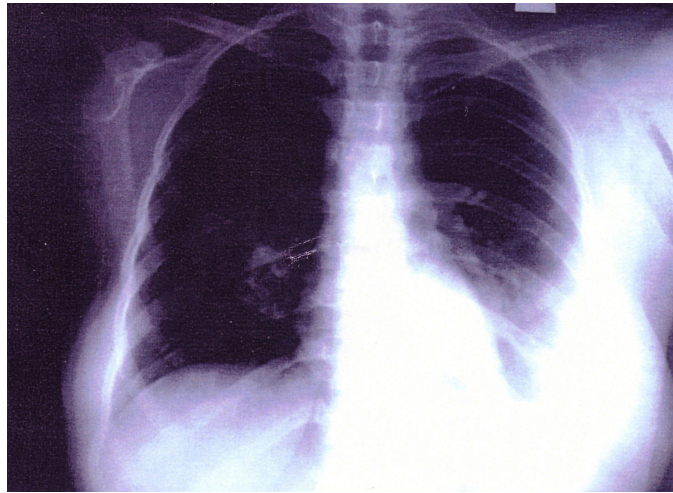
Chest X-Ray of the right lung showed two round masses in the middle zone
